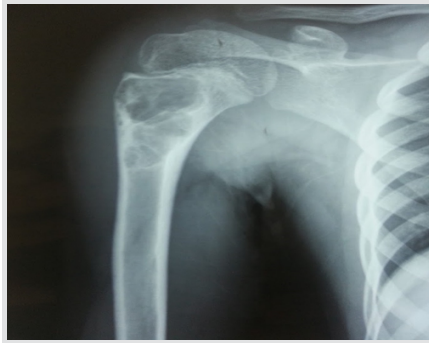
Radiograph of proximal humerus showing Grade 3 capanna Stage 2 lesion proximal humerus with soap bubble appearance likened to be aneurysmal bone cyst.
